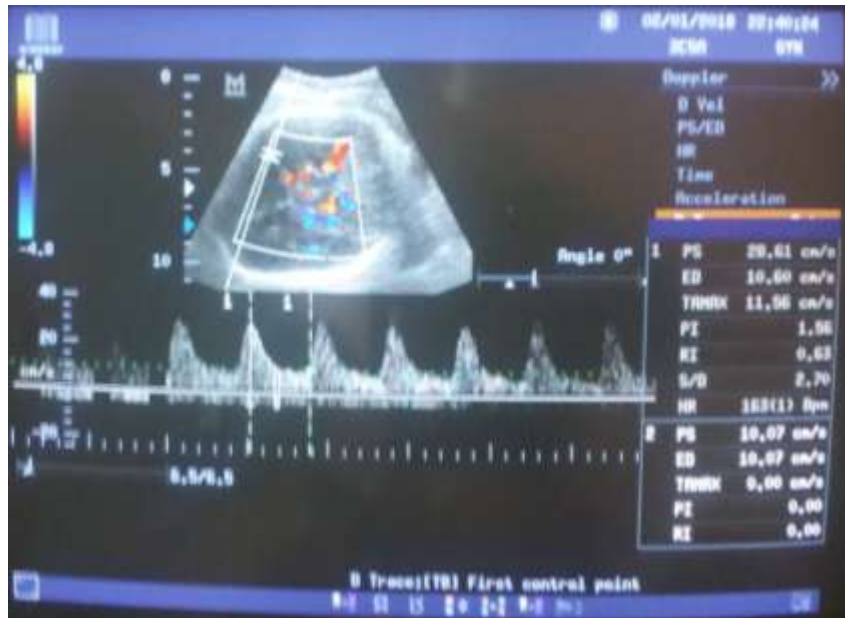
b) shows color Doppler middle cerebral artery waveform at 43
